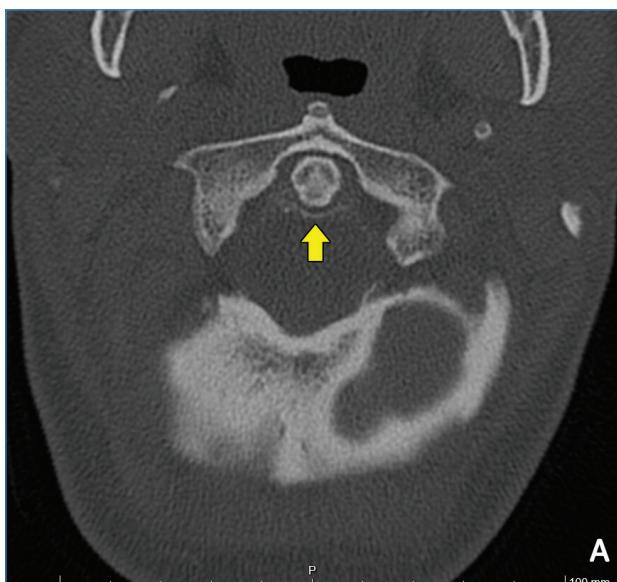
Axial cervical spine CT image of a 44-year-old female
